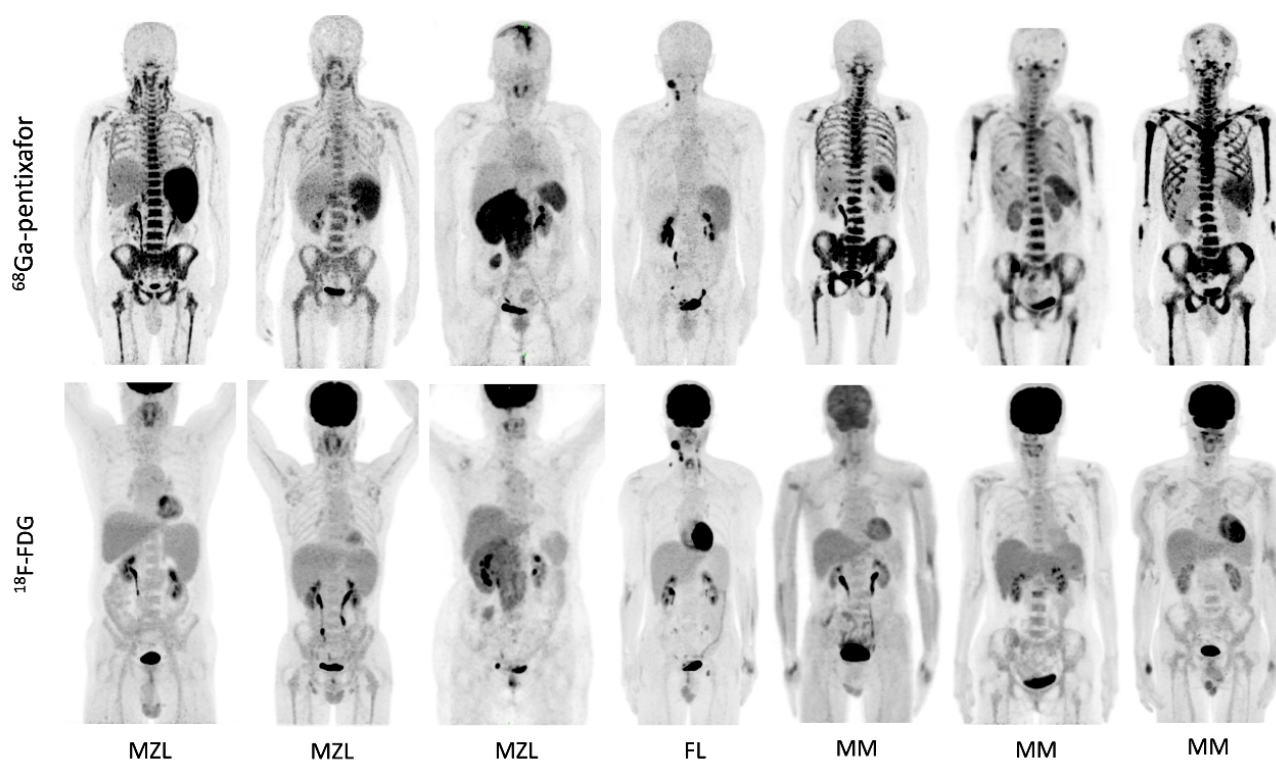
Individual comparison of lymphoproliferative diseases shown on ^{68}Ga -pentixafor and ^{18}F -FDG PET/CT. Gallium-68-pentixafor PET showed obviously higher intensity than ^{18}F -FDG uptake in marginal zone lymphoma (MZL) and multiple myeloma (MM) with more intense uptake in involved bone marrow, lymph nodes, as well as extra-nodal lesions. In follicular lymphoma (FL), ^{68}Ga -pentixafor and ^{18}F -FDG PET detected involvement of cervical and inguinal lymph nodes with comparable uptake of both tracer.
